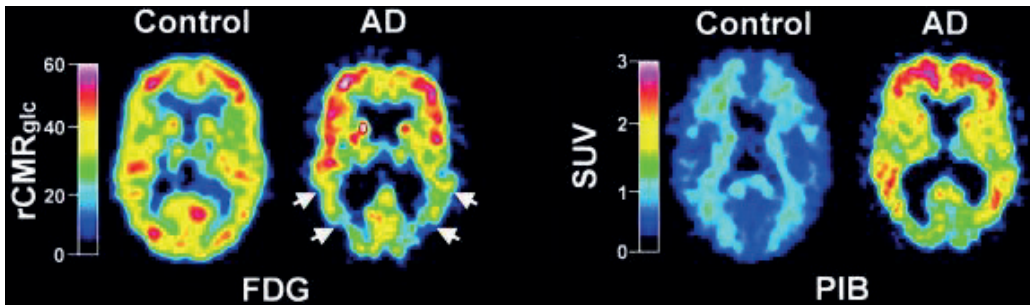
Examples of fluorine 18-fluorodeoxyglucose positron emission tomography (^{18}F -FDG-PET) (left) and Pittsburgh compound B (PiB) uptake in a 67-year-old control subject and a 79-year-old Alzheimer's disease (AD) patient. FDG-PET shows reduced glucose metabolism (arrows) and PiB-PET increased PiB uptake in the AD patient compared to the healthy control. rCMRglc = glucose metabolic rate in $\mu\text{mol}/\text{min}/100\text{ml}$, SUV = standardized uptake value. Reprinted from Klunk et al. (2004) with permission from John Wiley & Sons Inc.
